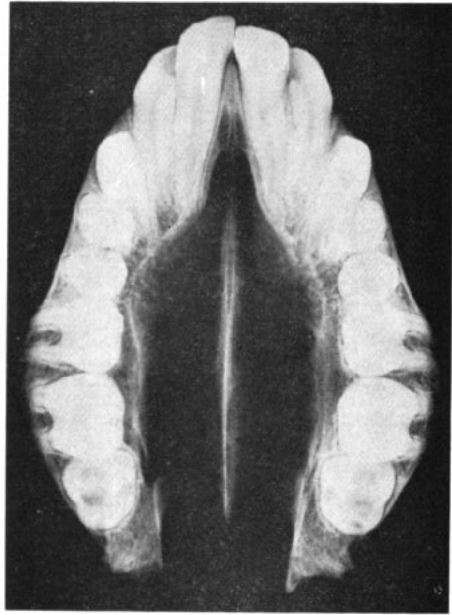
Occlusal radiograph of palatal region showing normal sutural morphology.
